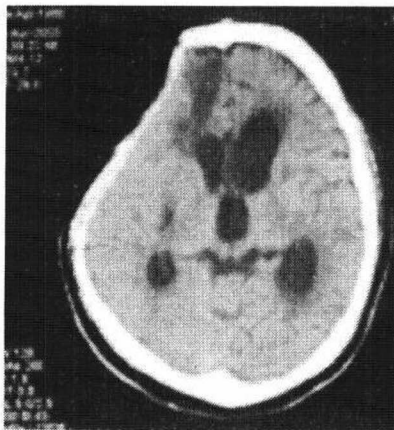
A : Brain computed tomography of a patient with decompressive craniectomy in right frontotemporoparietal bone and hydrocephalus, B(after 3 hours), C(after 6 hours), D(after 24 hours) : Radioisotope cisternography of same patient showing rarely activity of isotope lateral to the ventricle in posteroanterior view.
